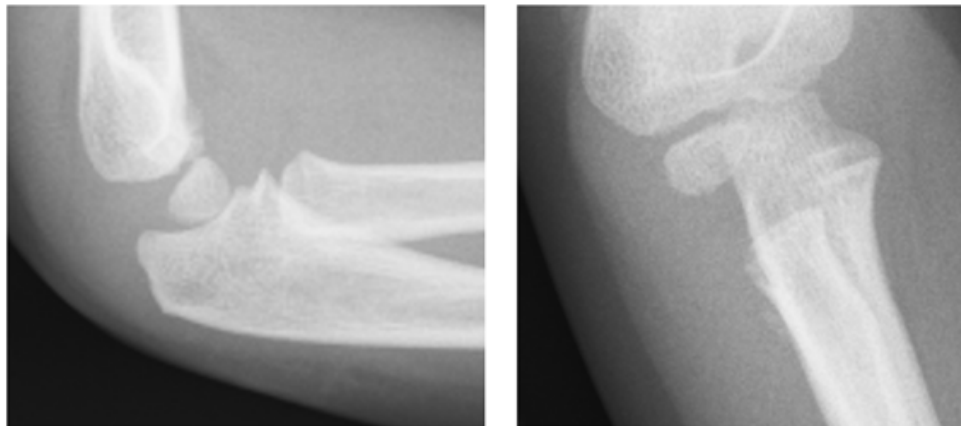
X-rays after elbow trauma at the age of 5. The small bone shadow lateral to the proximal radial metaphysis was overlooked.
